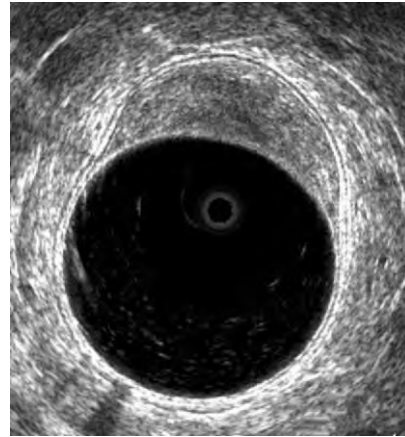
Benign villous tumor of the rectum (uT0). The middle white line is intact around the entire breadth of the tumor, indicating that the submucosa is not involved. (From Wong WD, Orrom WJ, Jensen LL: Preoperative staging of rectal cancer with endorectal ultrasonography. *Perspect Colon Rectal Surg* 3:315, 1990.)
